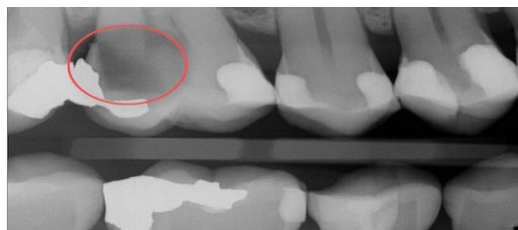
dental caries xrays ⁽²⁵⁾
